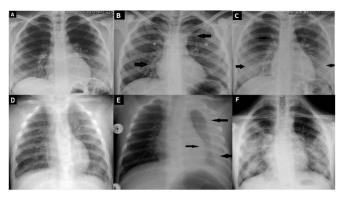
PA Chest X-ray imaging findings of hospitalized patients with a diagnosis of COVID-19. (A): A 13-year-old female patient who was asymptomatic. Normal PA chest X-ray graph. (B): A 14-year-old male patient with dyspnea. Pneumothorax on the left and increased vascularity on the right. (C): A 12-year-old female patient with complaints of fever, headache and sore throat. Bilateral ground glass density. (D): A 6-month-old male diagnosis of hemophagocytic patient with а lymphohistiocytosis, with cough, fever and shortness of breath, died on the 14th day of his hospitalization while being treated in the intensive care unit. Bilateral ground glass density and consolidation. (E): A 2-month-old female patient who was treated in the intensive care unit with complaints of fever and shortness of breath. Left pleural effusion. (F): A 17-year-old male patient Syndrome diagnosed with Down and Acute Lymphoblastic Leukemia, with complaints of fever, cough and shortness of breath, and died on the 4th day of his hospitalization while being treated in the intensive care unit. Bilateral ground glass density and consolidation.
